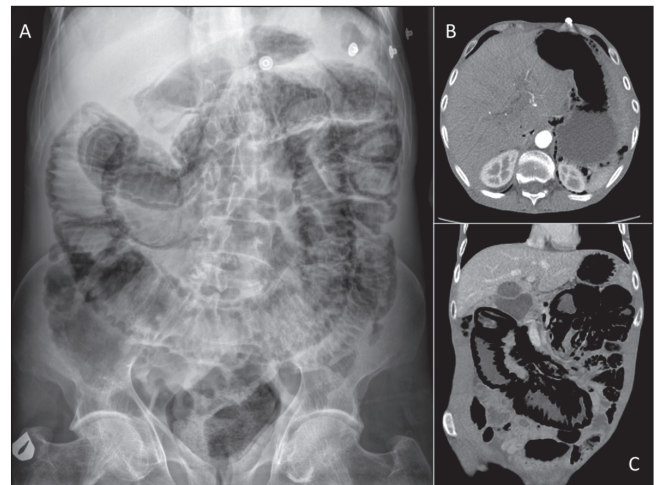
A. Plain abdominal X-ray showing distended small bowel loops and pneumatosis, this was also observed in the stomach. B-C. CT scan demonstrating retroperitoneum and extensive gastric (B) and small bowel (C) pneumatosis.
